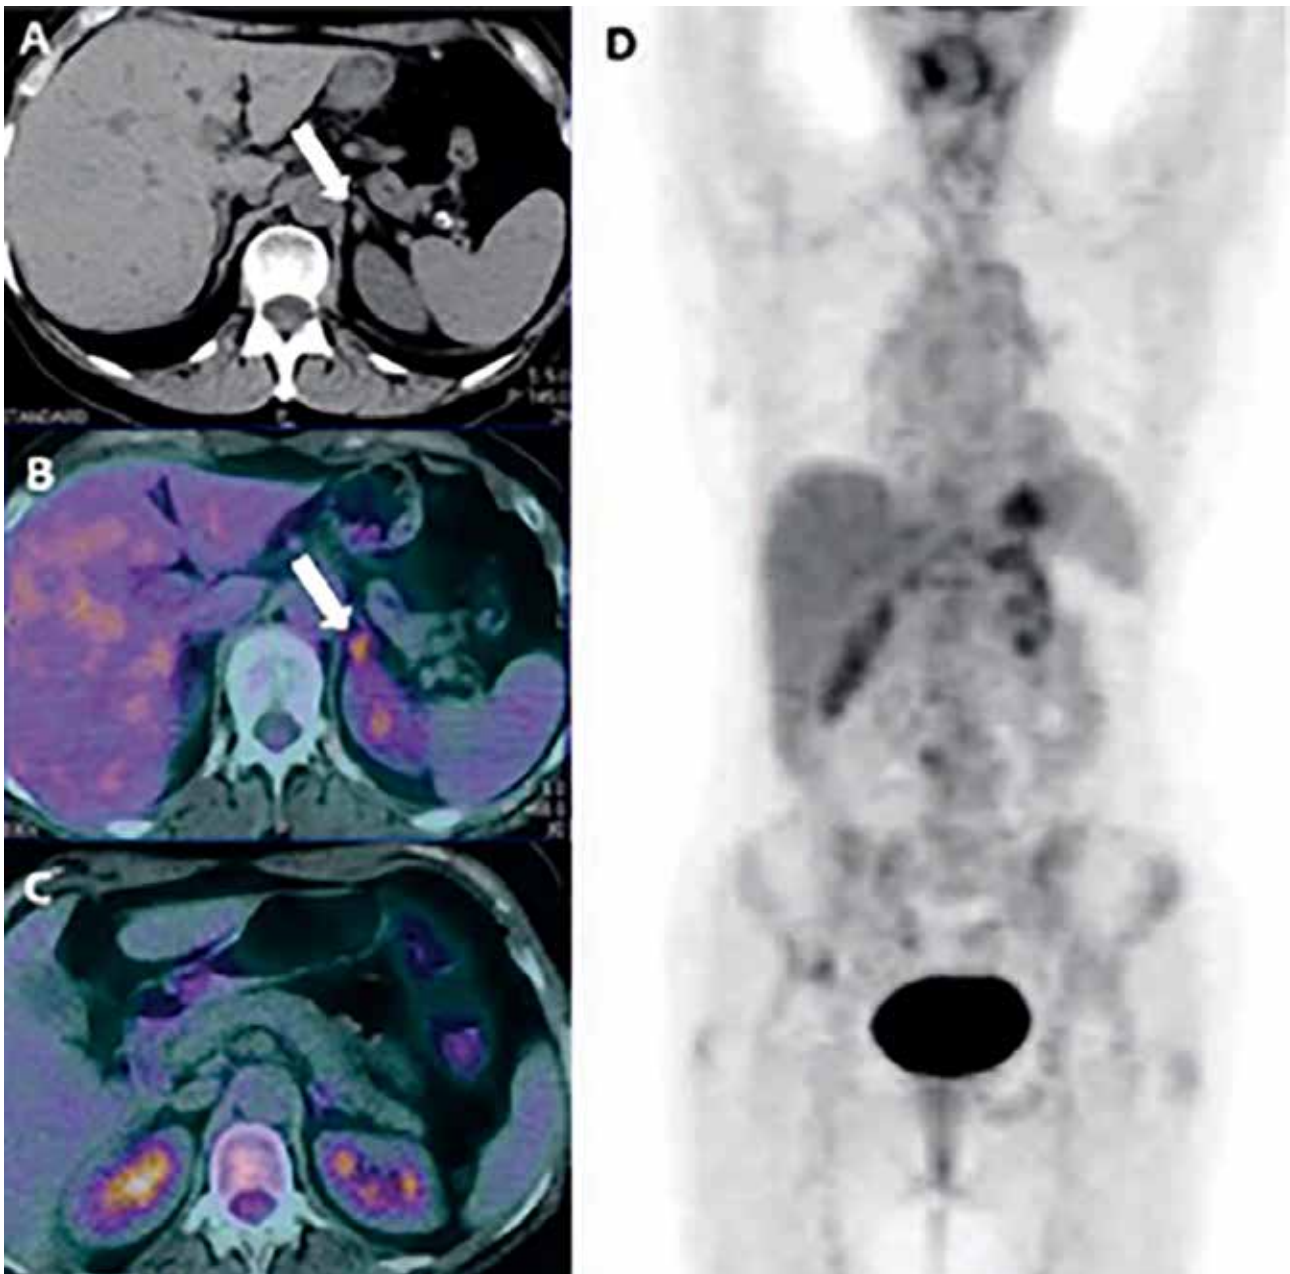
Increased ^{18}F -FDG metabolic activity shows lymphoma of the left adrenal gland (arrow) on axial unenhanced CT (A) and ^{18}F -FDG PET/CT (B). Resolution of the disease after chemotherapy is determined on axial PET/CT (C) and coronal PET (D) images. (Cistaro A, Asabella AN, Coppolino P, Quartuccio N, Altini C, Cucinotta M, Alongi P, Balma M, Sanfilippo S, Buschiazzo A et al. Diagnostic and prognostic value of ^{18}F -FDG PET/CT in comparison with morphological imaging in primary adrenal gland malignancies – a multicenter experience. *Hell J Nucl Med* 2015; 18(2): 97-102)
